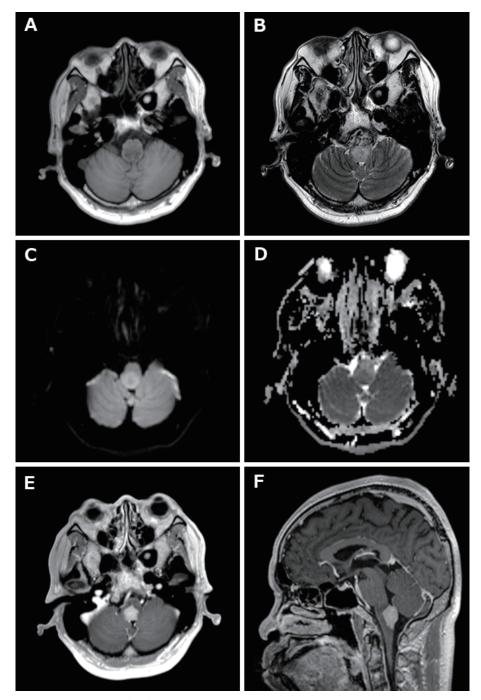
Initial brain magnetic resonance (MR) images showing a space-occupying lesion in the medulla oblongata. It was observed in hypointensity on the T1 weighted image (T1WI) (A) and hyperintensity on T2WI (B) but only a minor elevation of signal intensity on the diffusion-weighted image (DWI) (C) and with poor apparent diffusion coefficient reduction (D). It was homogenously enhanced with gadolinium, and axial (E) and sagittal (F) images are shown.
